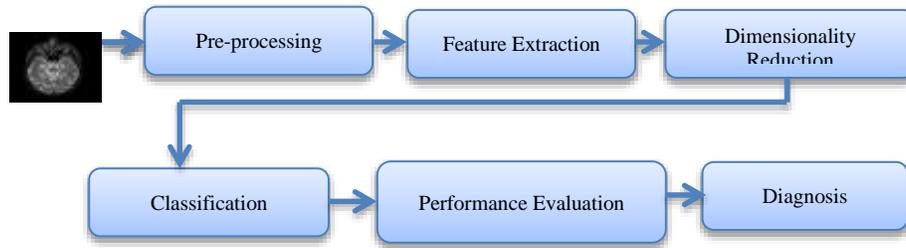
Methodology of Brain MRI Classification.
